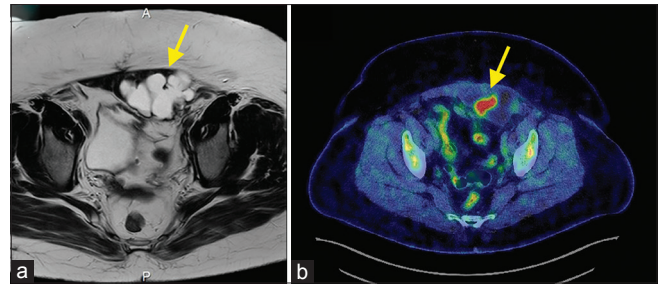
Tumor appearance. (a) Contrast-enhanced magnetic resonance imaging, T2-weighted axial aspect, showing polycystic mass arising from the abdominal wall (arrow), (b) 18F-fluorodeoxyglucose-positron emission tomography/computed tomography showing an increased uptake in the mass (maximum standardized uptake value: 15.69) (arrow)
